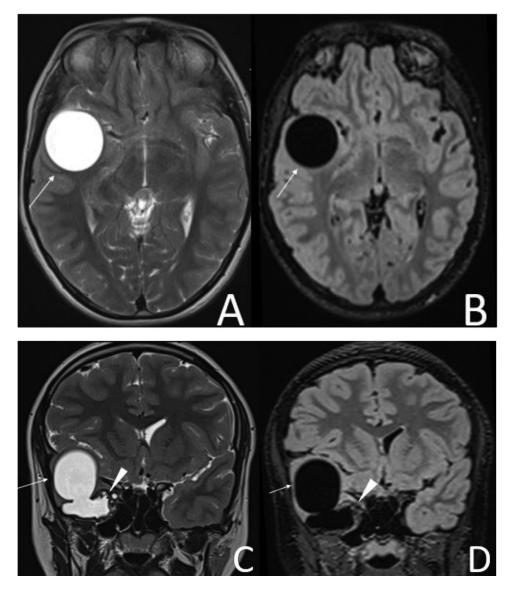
MRI T2 weighted and Flair images on axial (A and B) and coronal view (C and D) showing a well-defined cyst in the temporal lobe (white arrow). Images with coronal view (C and D) demonstrate also a multivesicular cyst (white head arrow).
